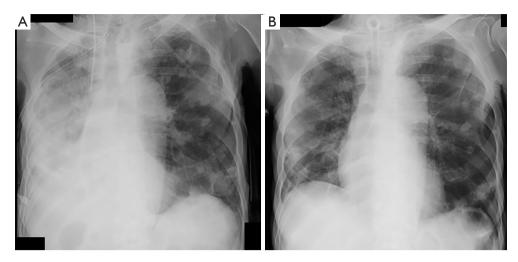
Chest radiograph findings. (A) One week after right chest tube drainage, the patient developed right-sided pneumonia. (B) One week after removal of chest tubes, no pneumothorax was observed.
